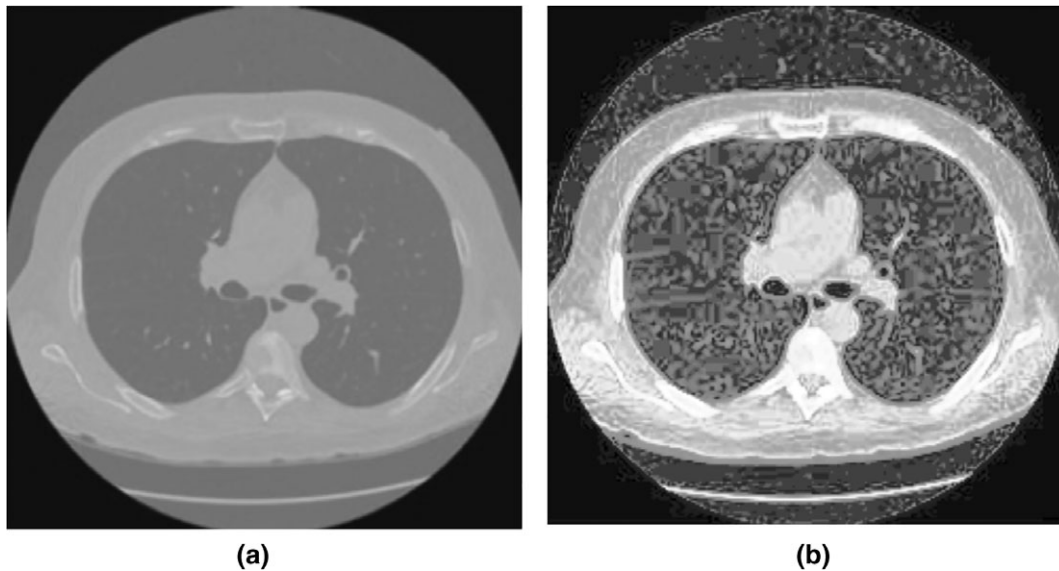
CT image before and after contrast enhancement. (a) Before contrast enhancement and (b) after enhancement
